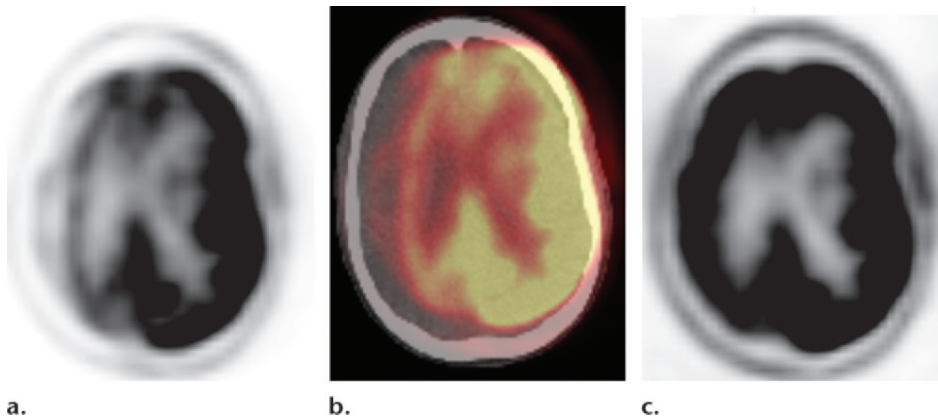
Attenuation correction artifact due to misregistration. (a) Non-attenuation-corrected image shows no region of decreased activity. (b) On a fused PET/CT image, the datasets are not properly coregistered. This “misalignment” between the anatomic and metabolic images causes an artifact with apparent diminished activity. (c) Attenuation-corrected image shows a region of decreased activity, a finding that is artifactual and due to patient motion. Viewing the non-attenuation-corrected and fused PET/CT images is an important quality control check, since patient motion can introduce attenuation correction artifacts.
